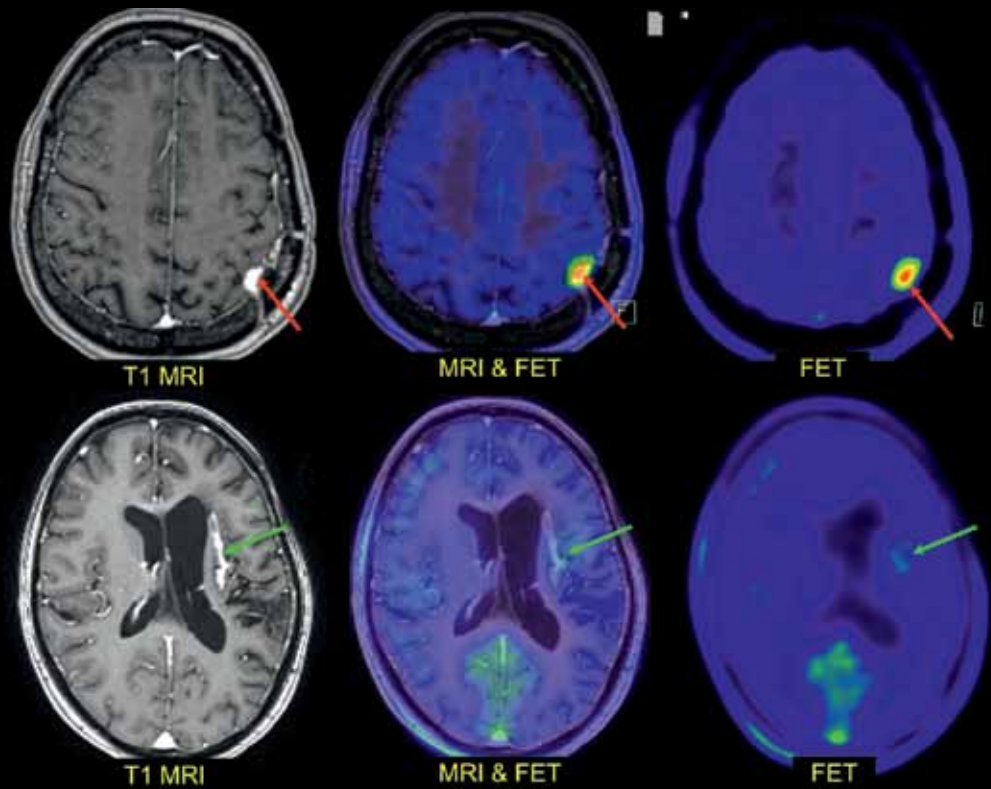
Two patients referred for the differentiation of recurrent high grade tumor or treatment damage? The top patient has recurrent and metabolically active tumor tissue (red arrow) and the bottom patient has treatment damage (green arrow). The images shown are T1 weight MRI after contrast, PET FET scanning and FET PET fused to MRI.
